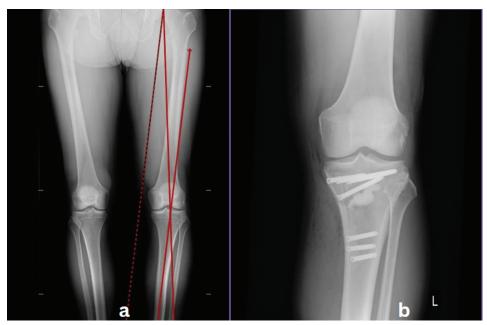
a - Preoperative radiograph reveals varus deformity of the left knee measuring 8.5 degrees, b - 1 year postoperative radiograph reveals healed site of the osteotomy
